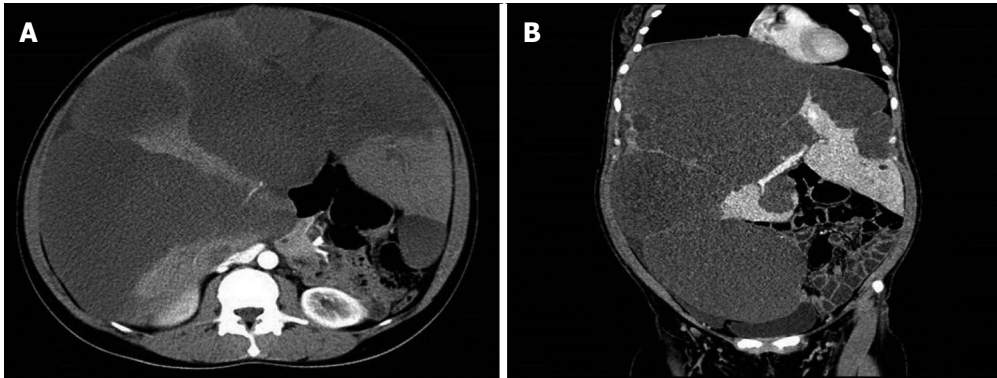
Contrast enhanced computed tomography of the abdomen revealed the near replacement of the liver with diffuse cystic masses of low density. A: Enhanced computed tomography scan shows the near replacement of the liver with diffuse cystic masses, leaving only small amounts of liver parenchyma. The portal vein and inferior vena cava are obviously compressed; B: The massively enlarged liver essentially occupies the entire abdominal cavity, with other abdominal organs being compressed and displaced.
